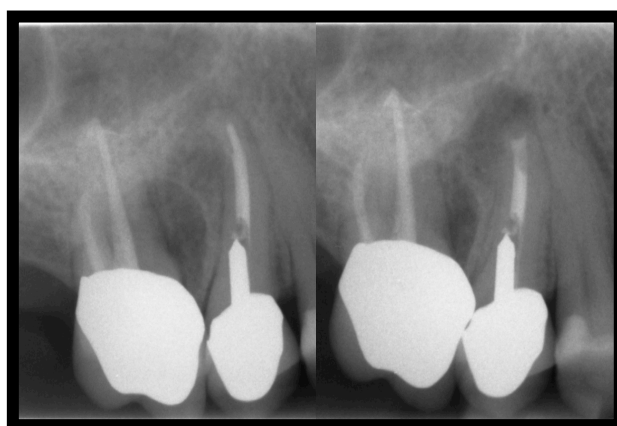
Left: MB root of 16 resected; Right: 15 retrofill postoperative radiograph
